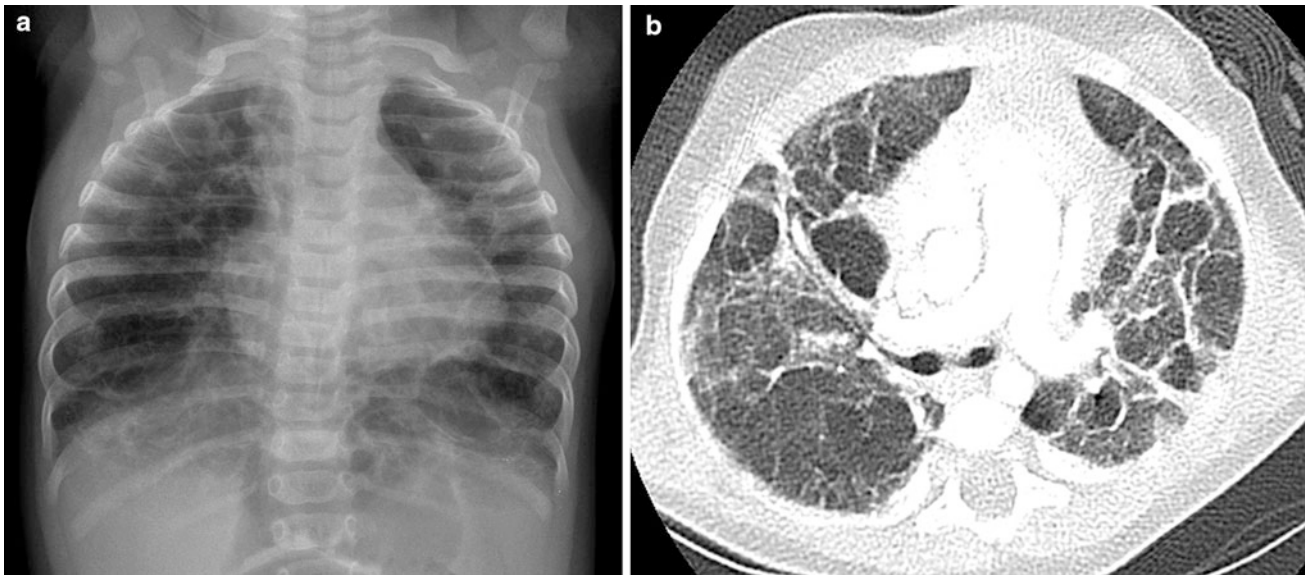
Growth abnormality. A frontal CXR (a) of a five-month-old former 32-week preemie with CLDI and continued supplemental oxygen requirement shows pulmonary hyperinflation, reticular opacities, and cystic changes. An axial chest CT image (b) demonstrates
